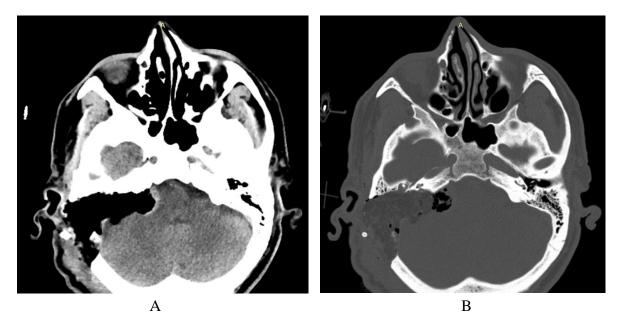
Computed tomography images showing: A - postoperative defect; B - obliteration of the postoperative defect with adipose tissue.
